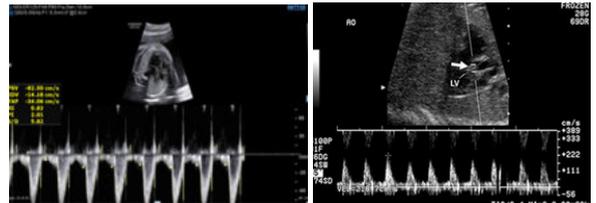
Doppler showing increased PSV of aorta near the stenosis
